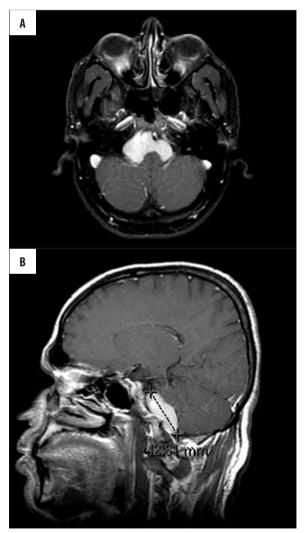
Contrast-enhanced axial (A), and sagittal (B) T1-weighted images of the brain show nonenhancement of the mass and cyst size of 4.2 centimeters in craniocaudal dimension (B).
